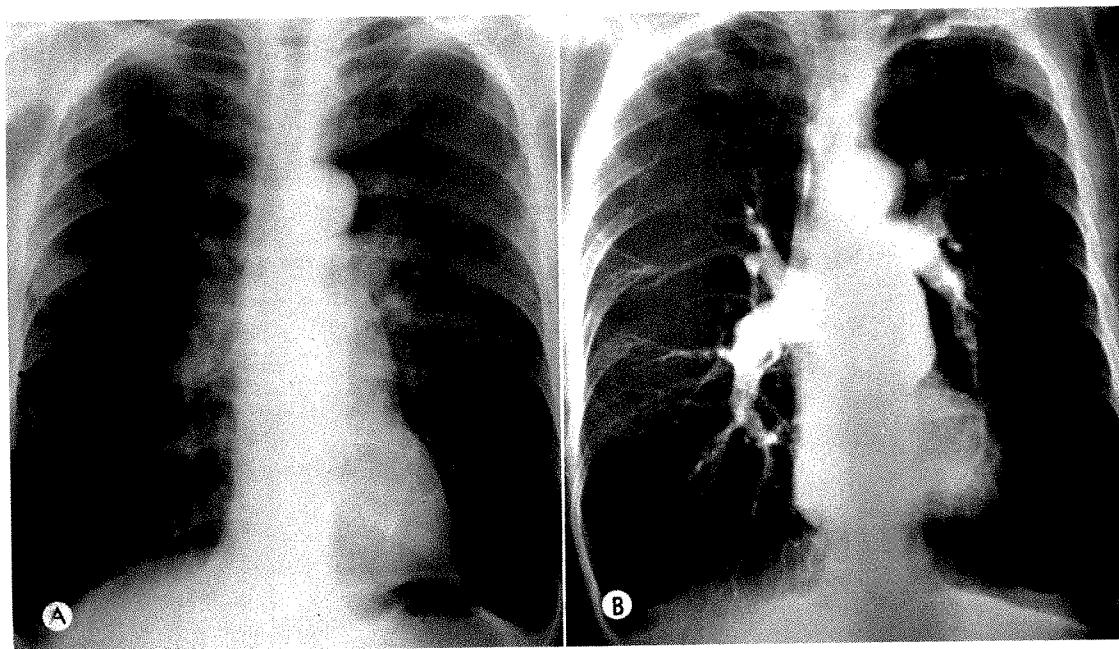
Case II. *Generalized and bullous emphysema also unsuited for surgery.* (A) Conventional frontal roentgenogram reveals a voluminous thorax with increased translucency of the lungs, especially the bases. The pulmonary artery segment is prominent. (B) Frontal angiocardigram shows enlargement of the pulmonary artery and branches. There is marked decrease in the pulmonary arterial tree, especially of the left lung. The right lung shows the wiry ("winter tree") pattern of generalized emphysema. The left lung shows the abrupt termination of the pulmonary arterial tree due to bullous emphysema.
